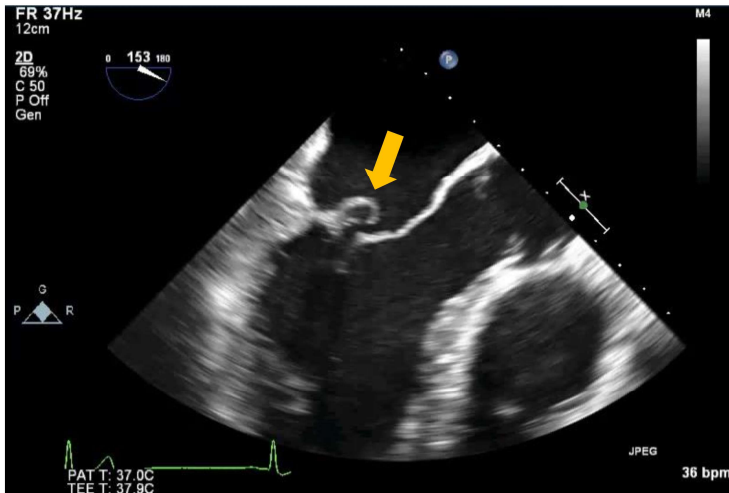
Echocardiographic image of pathological mitral valve during peak systole. The arrow indicates the prolapsing segment of the posterior leaflet
